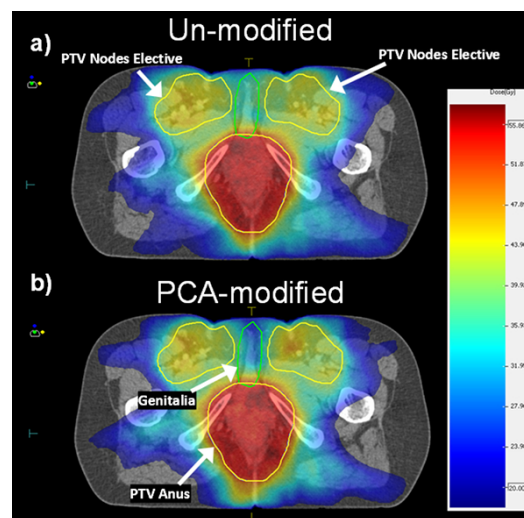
a) Axial CT slice of the 'Un-modified' plan without any optimisation of the genitalia DVH showing the dose distribution near the genitalia contour, the elective nodes PTV and the anus PTV. b) The dose distribution of the 'PCA-modified' plan demonstrating the dose reduction in the genitalia to reduce the probability of having vaginal stenosis symptoms. The genitalia dose reduction optimisation was based on cost functions constructed using information from the PCA-based modelling (Fig.2).
